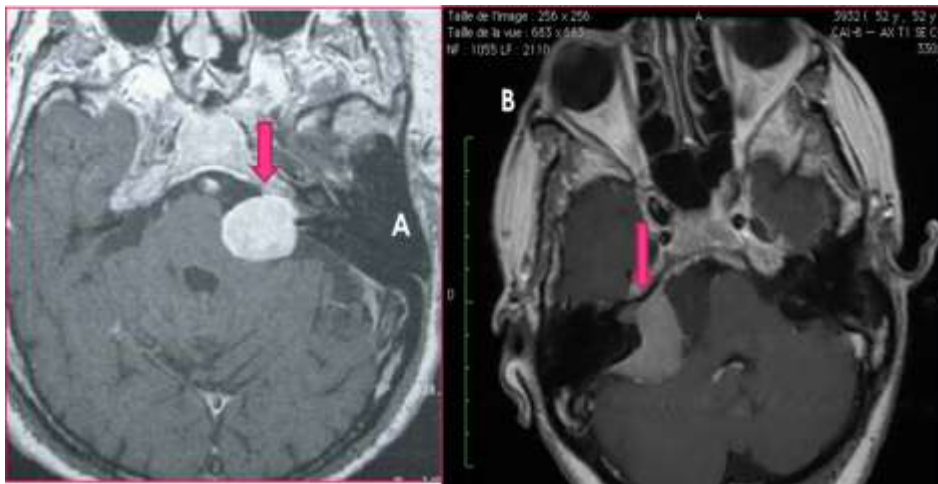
(A and B): MRI after injection of gadolinium in T1 showing tumors of the cerebellopontine angle (neurinoma VII (A) and meningioma (B))
